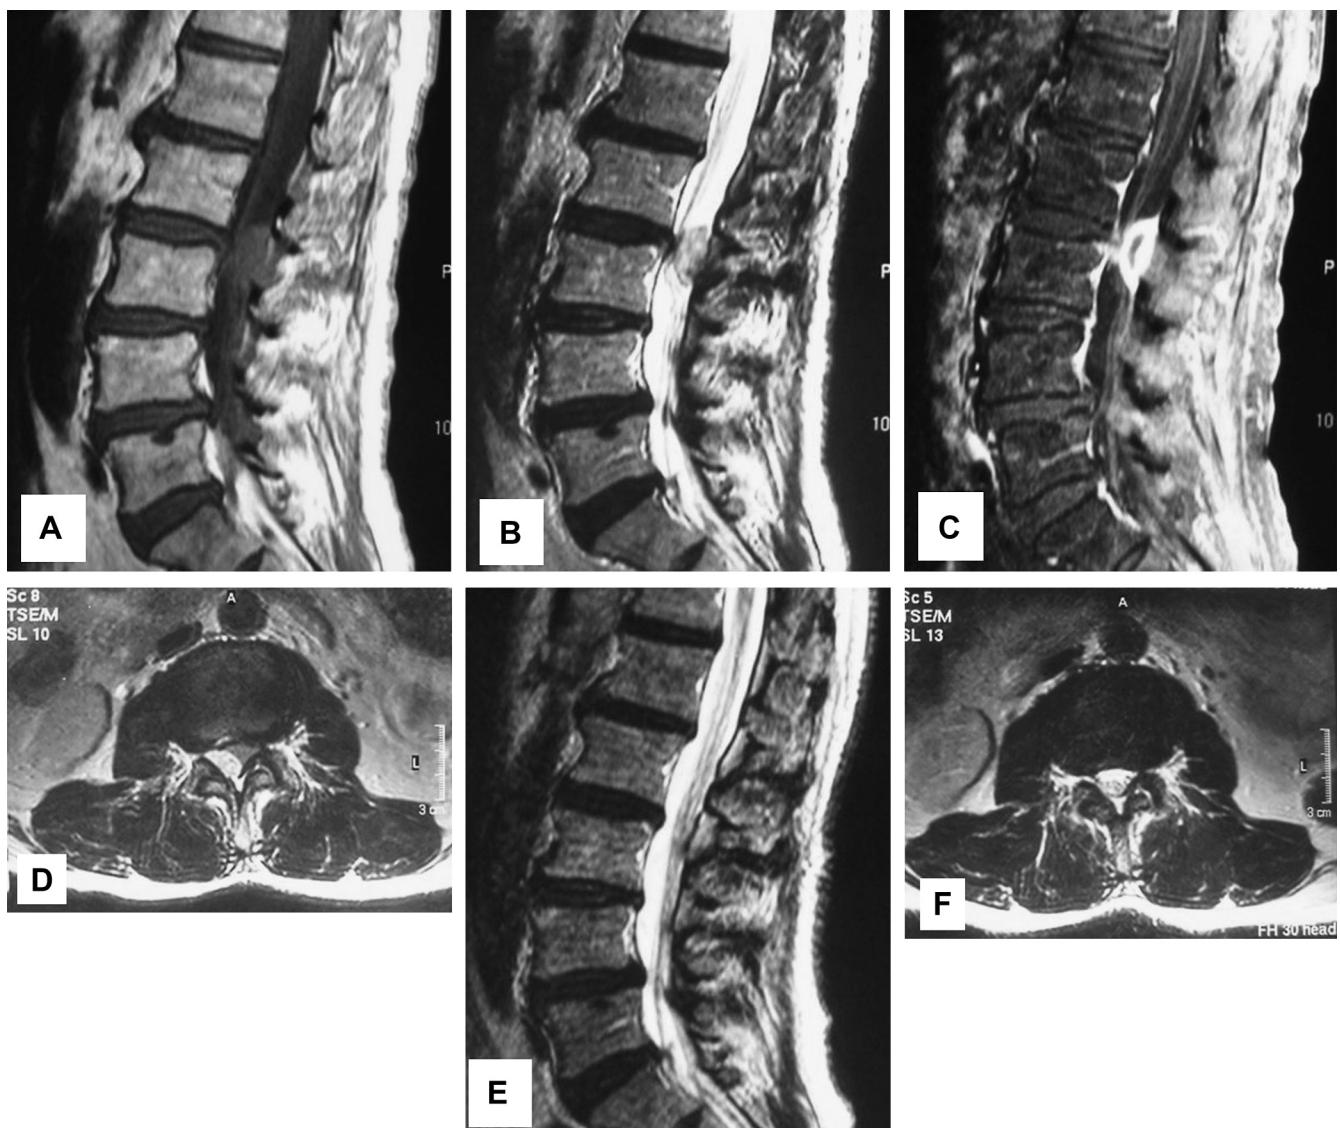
(A, B) Sagittal T1- and T2-weighted magnetic resonance imaging (MRI) showing the lesion in the posterior epidural space at L2–L3. (C, D) The lesion demonstrated rim enhancement on Gd-enhanced MRI. (E, F) The posterior epidural migrated lumbar disc fragments showed spontaneous regression on T2-weighted MRI 2 months after the first visit.
